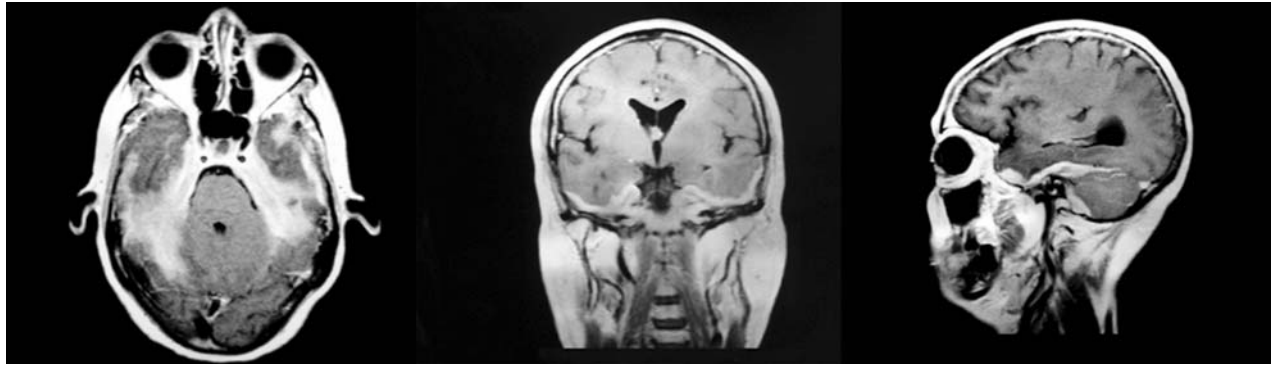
Pretreatment axial, coronal and sagittal views of a T1-weighted MRI after gadolinium enhancement. Diffuse thickening of the dura with oedematous changes in both anteromedial temporal and temporo-occipital lobes is evident
